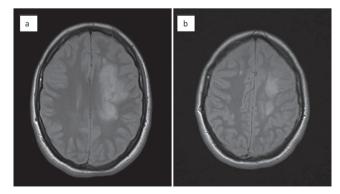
Cranial MRI (Axial section in Proton Density (PD)), case $n^{o} 2$: Extensive lesion in left frontal and parietal white matter. In b) Small white matter lesion in the left hemisphere is also observed
